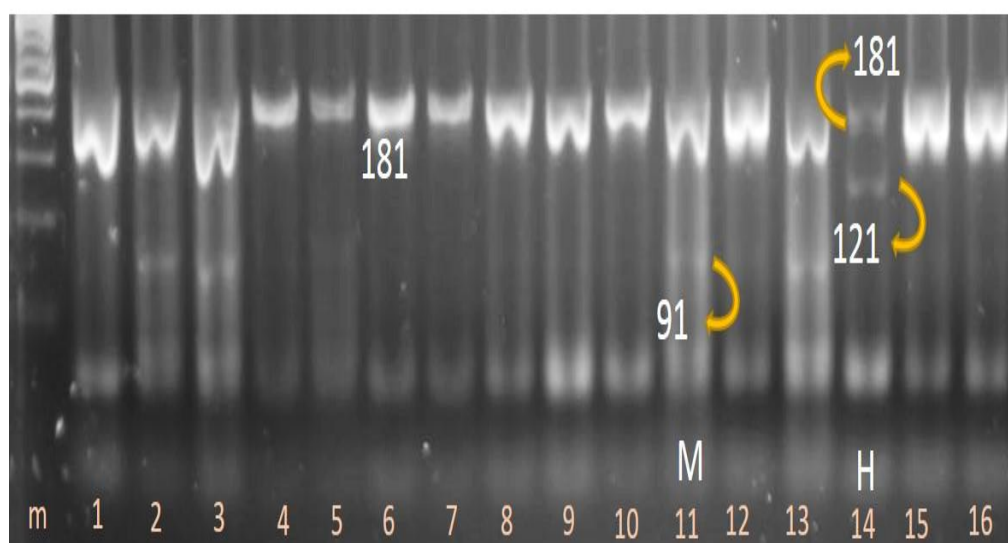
Cut pattern with Pst I in some study samples on agarose gel next to the 100 bp marker. Sample 11 indicates a homozygous person (CC), most samples indicate a homozygous person (TT) and sample 14 indicates a heterozygous carriers (CT) at this position.
